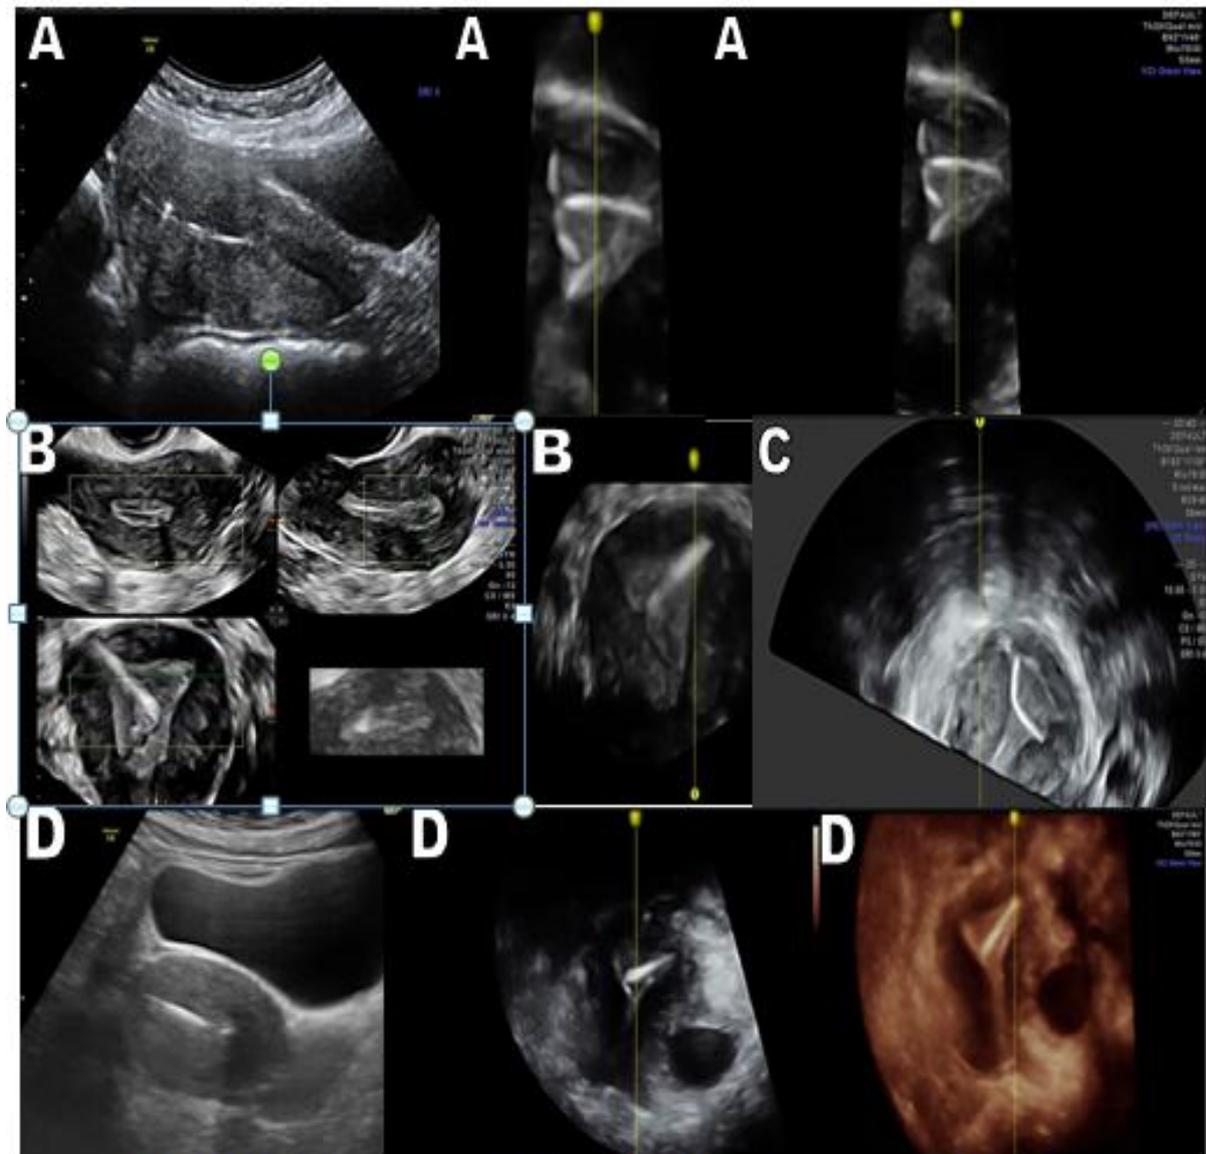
2D,3D and omniview VCI sonographic images for a four cases with abnormally rotated IUCD within the endometrial cavity, first, second and fourth cases images (A, B and D) display misdiagnosis of the IUCD rotation in 2D images and clearly portrayed in 3D and omniview VCI images, The third case image (C) displays slightly rotated IUCD with one of its arms seen migrating into the proximal segment of one of both fallopian tubes
